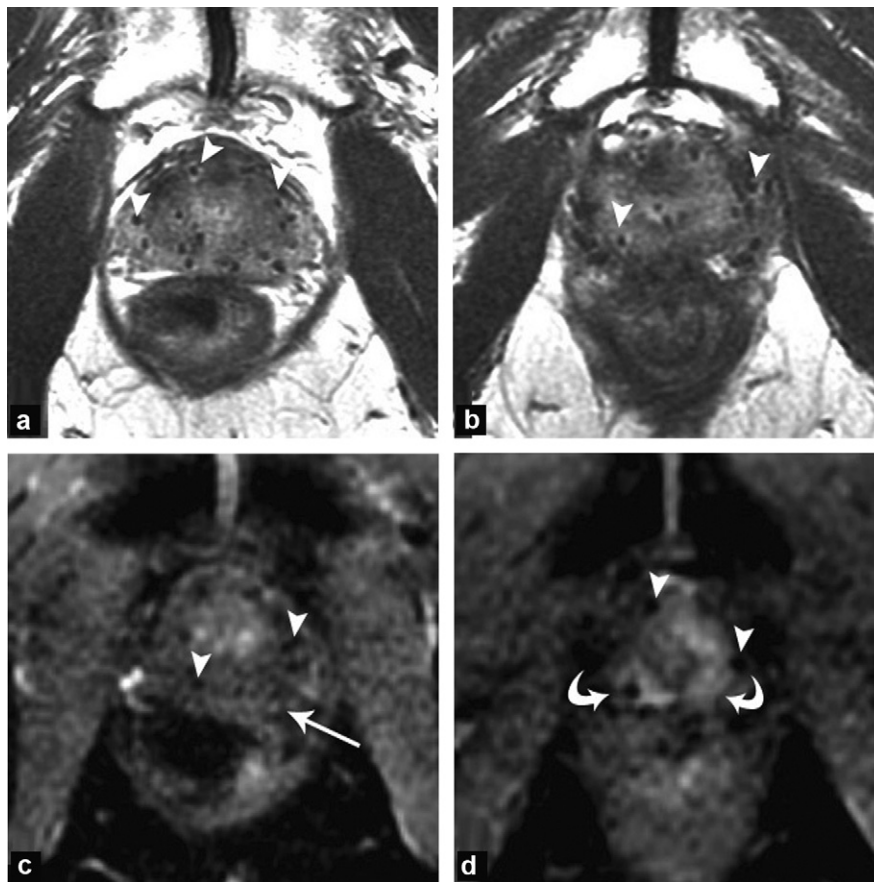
A 71-year-old patient treated with brachytherapy 8 years previously for a Gleason 6 prostatic adenocarcinoma with a PSA concentration of 8 ng/mL. Slow increase again in PSA to 5 ng/mL; a and b: T2-weighted axial magnetic resonance imaging (MRI) revealing a dedifferentiated prostate with no suspect area; c and d: dynamic axial slices after injection of contrast agent showing a peripheral area which is not enhanced (Fig. 9c, arrow), except at the apex where there is bilateral early enhancement (Fig. 9d, curved arrows). Note that the brachytherapy grains appear as small signal voids (Fig. 9a–d, arrowheads).
